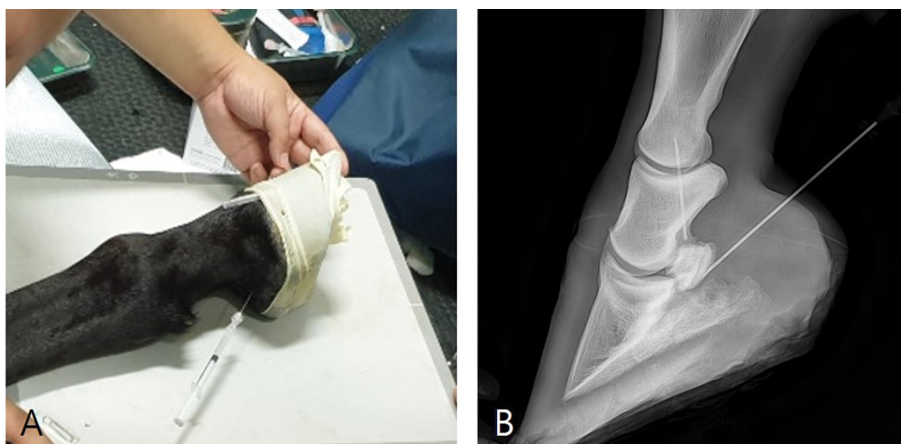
(A) Intra-bursal injection of the corticosteroid under aseptic conditions. (B) Accurate placement of the needle in the navicular bursa was confirmed by radiography.
